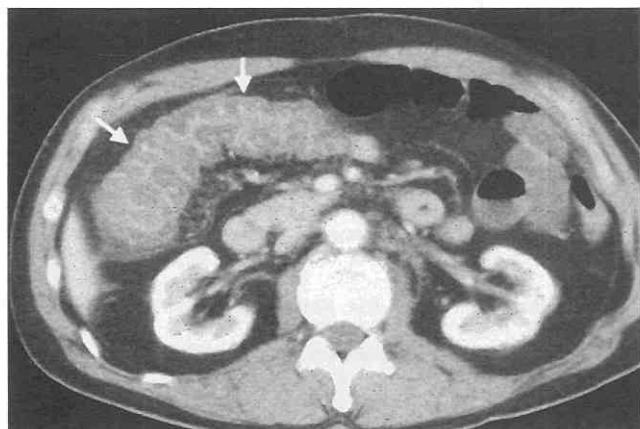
Colonic ischemia. CT scan shows heterogeneous colonic wall thickening (arrows) resulting from diffuse intramural hemorrhage or edema, which is confined to the right-sided colonic segment.
